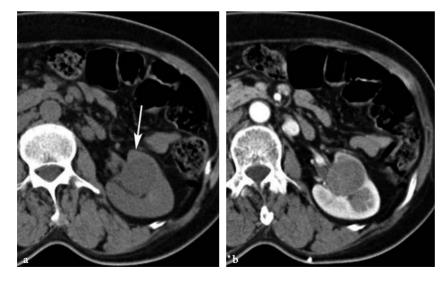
Collecting duct carcinoma in a 49-year-old man. a Axial unenhanced CT scan shows a hypodense mass (*arrow*) at the left renal medulla.b Axial contrastenhanced CT scan shows minimal enhancement of the tumor.
